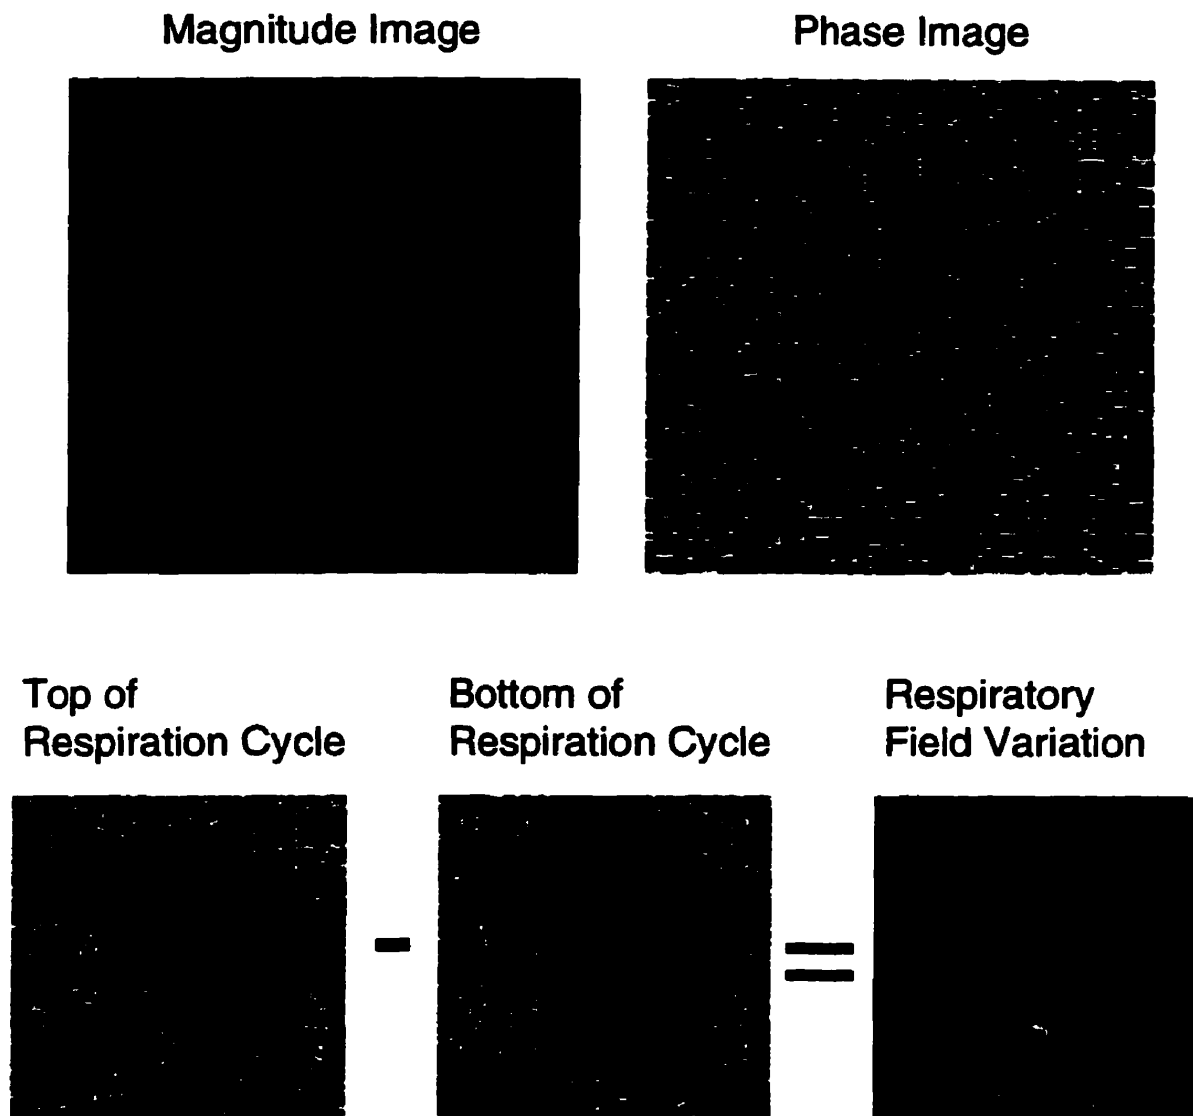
The phase part of MR images (usually discarded) contains information about the resonant frequency, hence field strength, at each point of an image. By acquiring T2*-weighted images with the reordered phase encode method (Fig. 2.10), phase images can be reconstructed corresponding to the top and bottom of the respiratory cycle. The difference between the phase images shows the B0 field variation that occurs with respiration.
